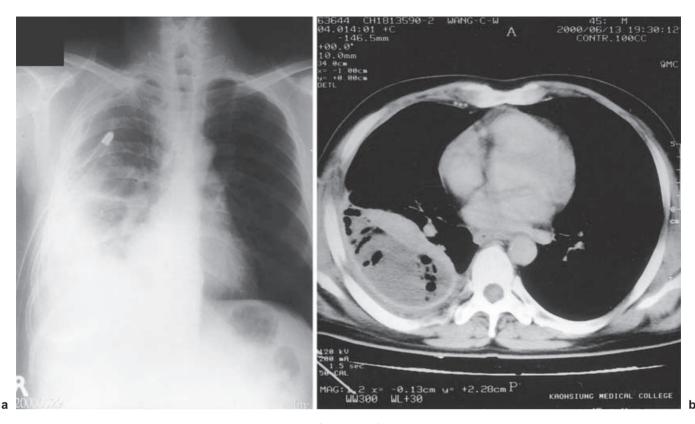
A 45-year-old man with right chronic empyema (presurgery). a Chest film after chest tube insertion. b Chest computed tomography showing thick pleura and collapsed lung
